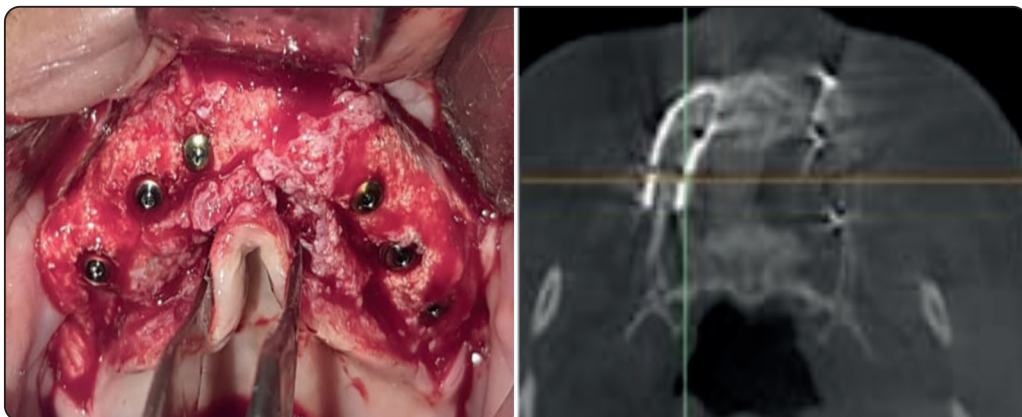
Showing post-operative condition of the alveolar ridge both clinically and radiographically .
